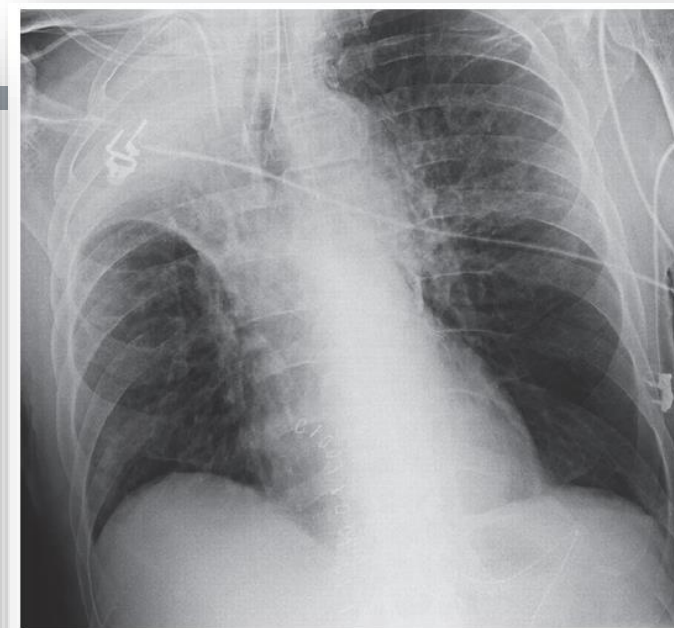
Radiograph showing right upper lobe atelectasis (courtesy of Professor Stephen Eustace, Dublin, Ireland).
